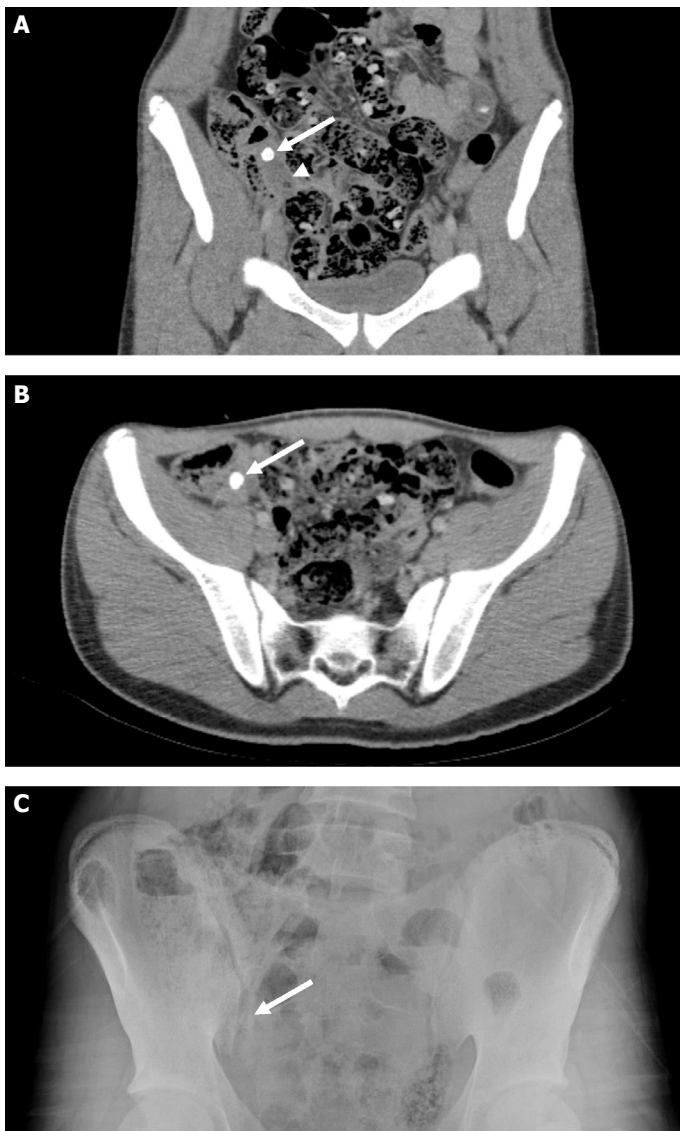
Nodular hyperdense appearance of an appendicolith (white arrow) obstructing the appendiceal lumen seen on coronal (A) and axial (B) planes of abdominal CT images from a patient with appendicitis (arrowhead shows the inflamed appendix). Nodular opacity of the appendicolith (white arrow) seen on direct abdominal radiograph (C) of the same patient.
